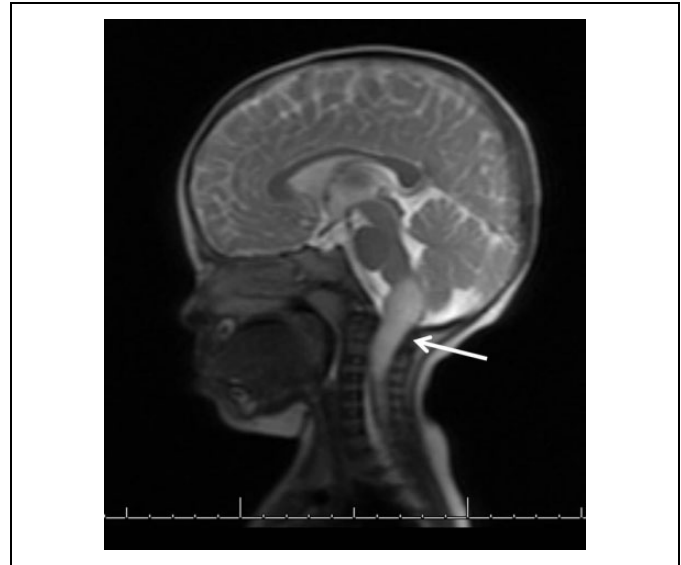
Sagittal T2 brain MRI with an intraparenchymal mass highlighted by the white arrow. MRI indicates magnetic resonance imaging.
